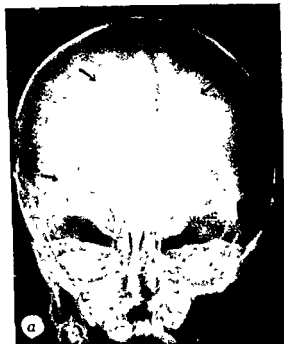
Roentgenograms revealing symmetrical calcification of cerebral basal ganglia and extensive calcification in cerebrum. Encephalitis in infancy.
